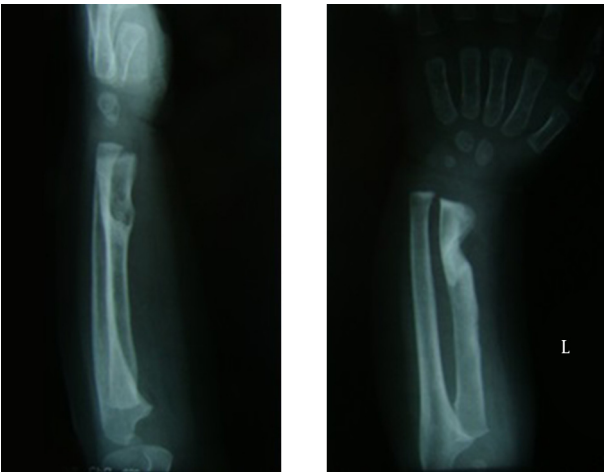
Radiography of the Wrist Showing the Typical Appearance, Case No. 3
